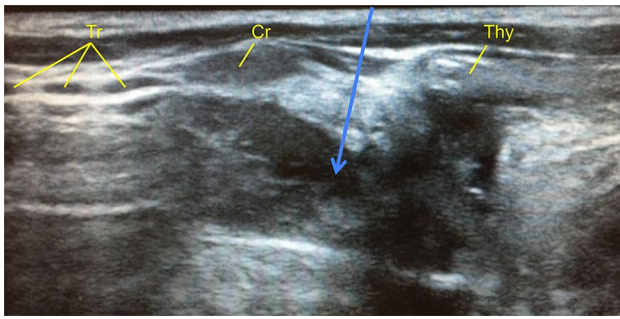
Identification of the cricothyroid membrane with ultrasonography (longitudinal view). The ultrasound transducer placing longitudinally in the *midline*, indicating the puncture site of cricothyroid membrane (*arrow*) between the thyroid cartilage (*Thy*) and cricoid cartilage (*Cr*), together with tracheal cartilages (*Tr*)
